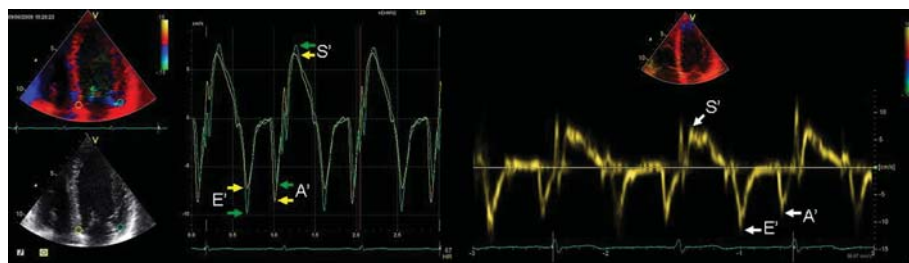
Left: velocity curves from colour Doppler tissue imaging in four-chamber view. Region of interest is positioned close to the septal and lateral insertion of the mitral leaflets, and peak systolic velocity (S'), early diastolic velocity (E') and late diastolic velocity (A') were measured at the peaks of the Doppler curve. Right: pulsed-wave tissue Doppler-derived septal annulus velocities with low gain setting in four-chamber long-axis view. S' , E' , and A' were measured at the maximum of the Doppler spectrum.
